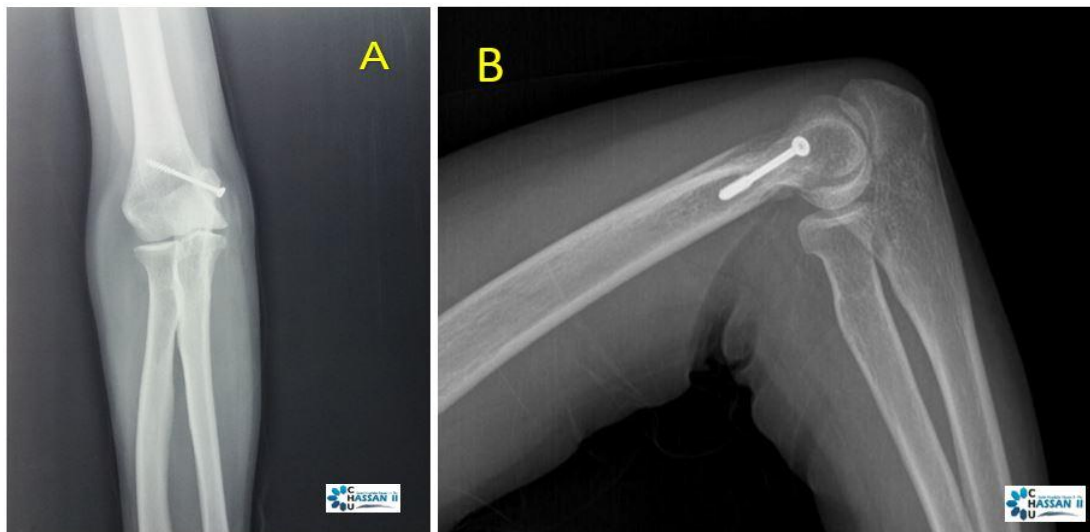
Standard frontal (A) and lateral (B) radiographs showed a consolidation of the fragment of the medial epicondylar
